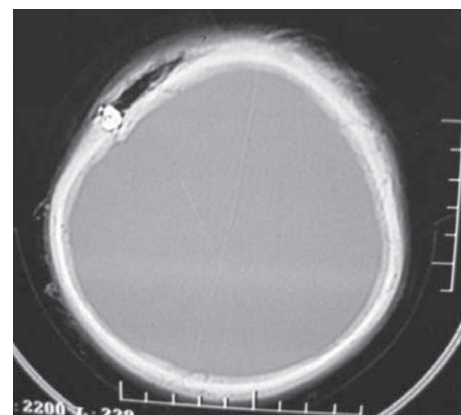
Bone window of CT head showing the depressed bone segment.
